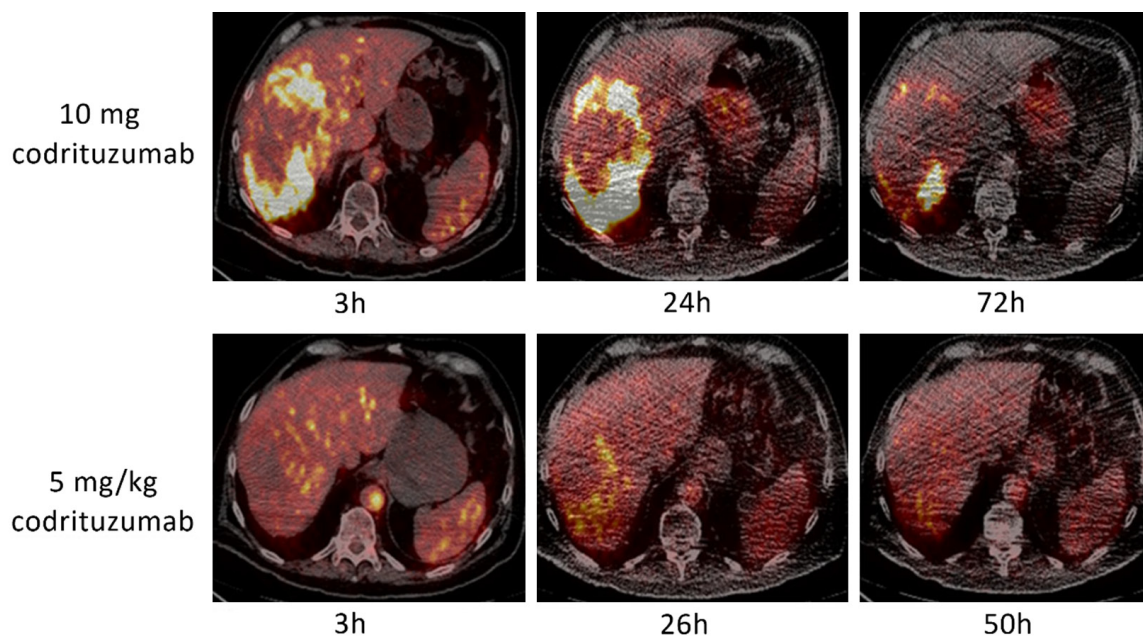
Representative imaging data for I-124 codrituzumab-PET/CT in a patient with HCC (adapted from the literature [32]).
